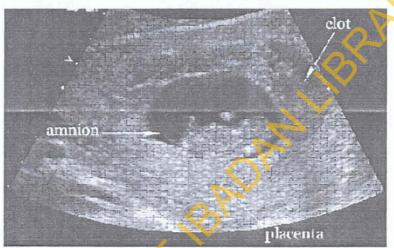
Obstetric ultrasound showing placenta abruption.
